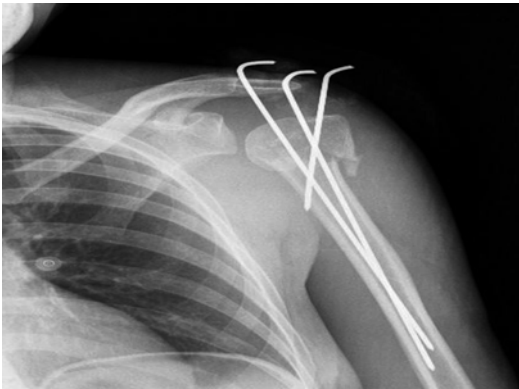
Postoperative X-ray of patient shown in Fig. 34.6 after placement of K wires
